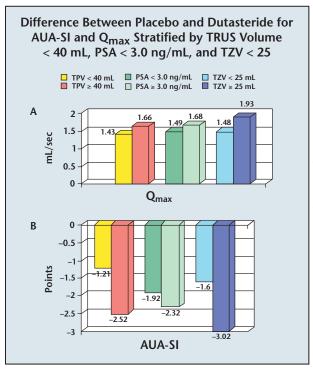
Difference between the average improvement in symptom score (A) and maximum flow rate (B) in placebo- versus dutasteridetreated patients stratified by total prostate volume (< and \ge 40 mL), transition zone volume (< and ≥ 25 mL), and serum PSA level (< and ≥ 3.0 ng/mL). A greater difference between placebo and dutasteride, ie, a more significant clinical efficacy, is evident for both outcomes and all 3 stratification for the larger glands with higher PSA values. AUA-SI, American Urological Association-Symptom Index; Qmax, maximum urinary flow rate; TRUS, transrectal ultrasound; PSA, prostate-specific antigen; TZV, transition zone volume; TPV, total prostate volume. Data on file, GlaxoSmithKline.19
